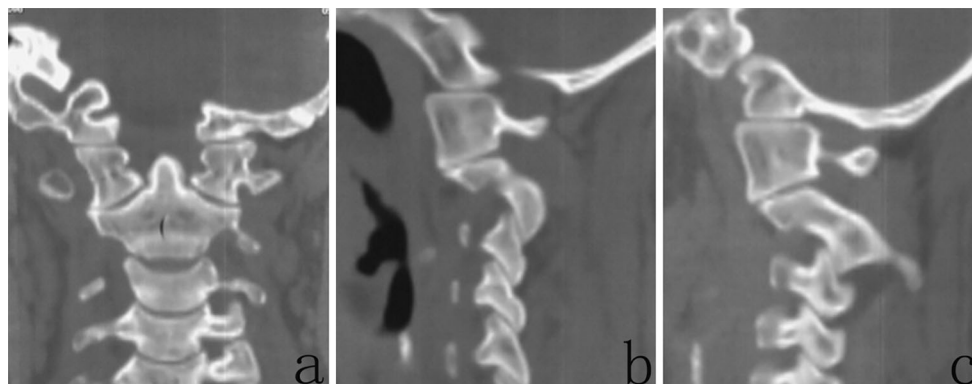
Computed tomography on a coronal reconstruction view a showed a loss of slope of the atlantooccipital joint. That on sagittal reconstruction views (b Rt, c Lt) also showed a flatness of the atlantooccipital joint on both sides
